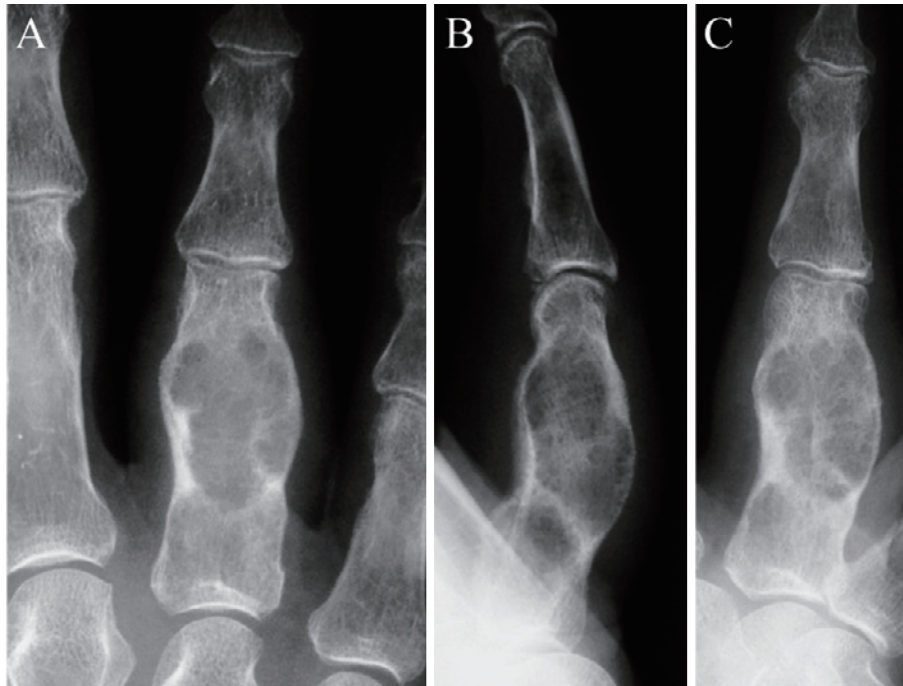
Radiographs of the right ring finger of a right-handed 88-year-old man, showing multilobate radiolucent region without calcification when he initially visited our hospital.
